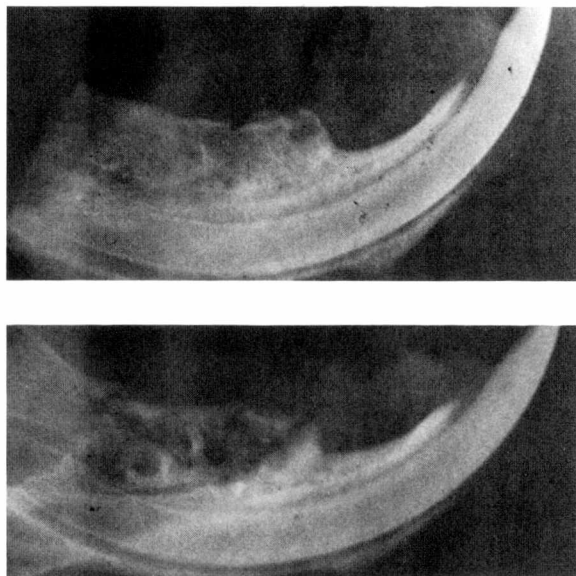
Radiographic appearance 14 days after the extraction. Upper: control; lower: experimental.
